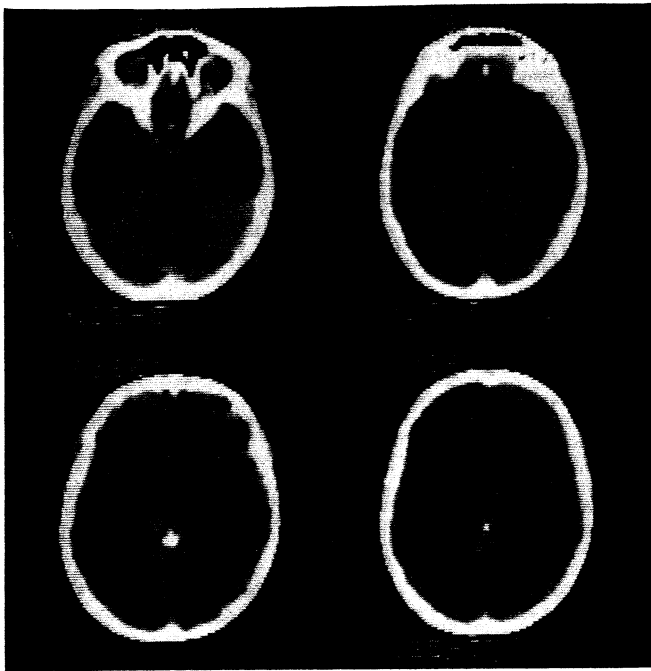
Case 2, first CT scan with enhancement: A small enhancing mass is present in the suprasellar cistern. A separate, large mass involves the pineal and is associated with an abnormal calcification. Transventricular spread is indicated by enhancement of the walls of both frontal horns. There is a mild obstructive hydrocephalus.
